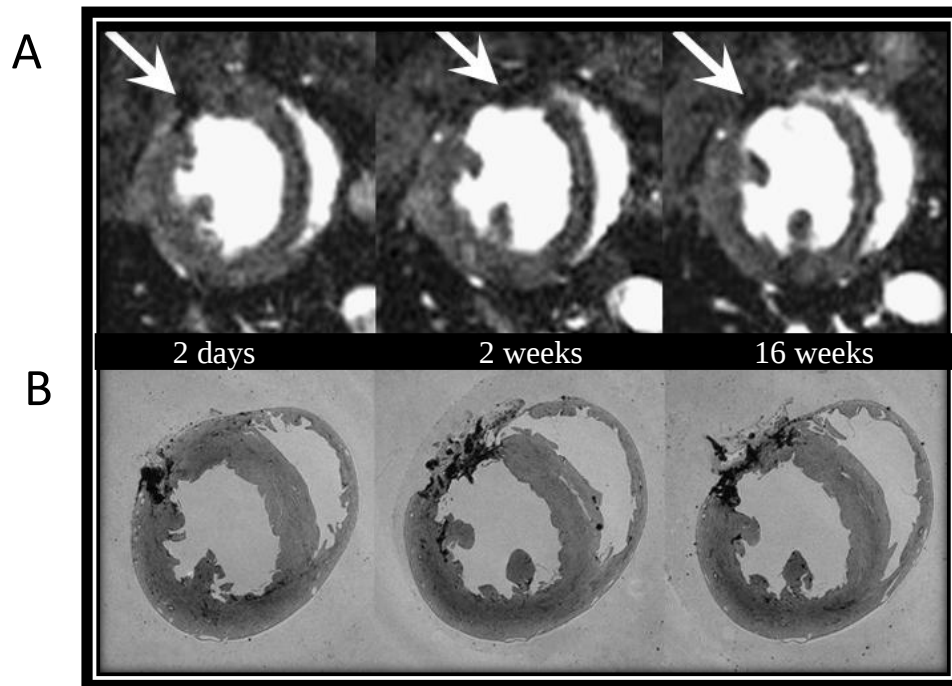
Colocalization of signal void and MPIO location in the CDC-treated hearts using in vivo and ex vivo MRI. Hypointense contrast (arrows) generated by MPIO-labelled CDCs was detected in the infarcted heart ($n=7$) using in vivo MRI (A) 2 days, 2 weeks, and 16 weeks after administration, which matched the signal void location seen in ex vivo MR images (B) of the corresponding heart ($n=2$). (work performed by Dr. Carolyn Carr and Dr. Daniel Stuckey)
